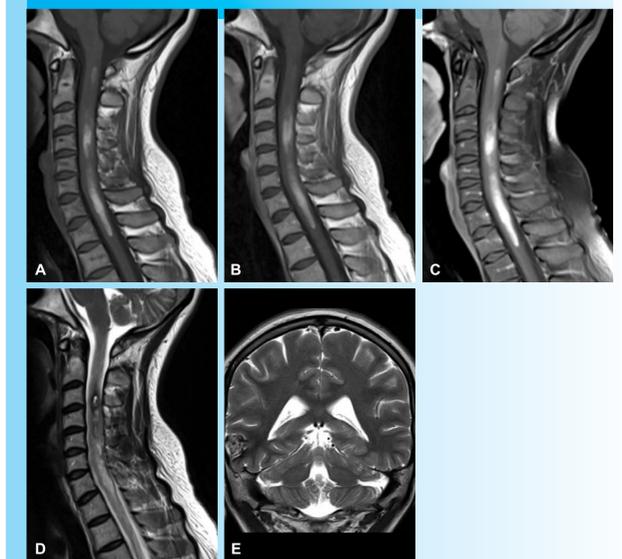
Sagittal T1-weighted MRI of a 31 year old patient. Precontrast (A) and postcontrast without (B) and with (C) fat saturation shows multiple foci of T1 hyperintensity in the cervical spinal cord. Altered cord-to-background contrast with fat saturation could be misleading. Sagittal T2 (D) shows heterogeneous signal intensity. Brain MRI (E, coronal TSE T2) demonstrated typical right temporal lobe CM.
